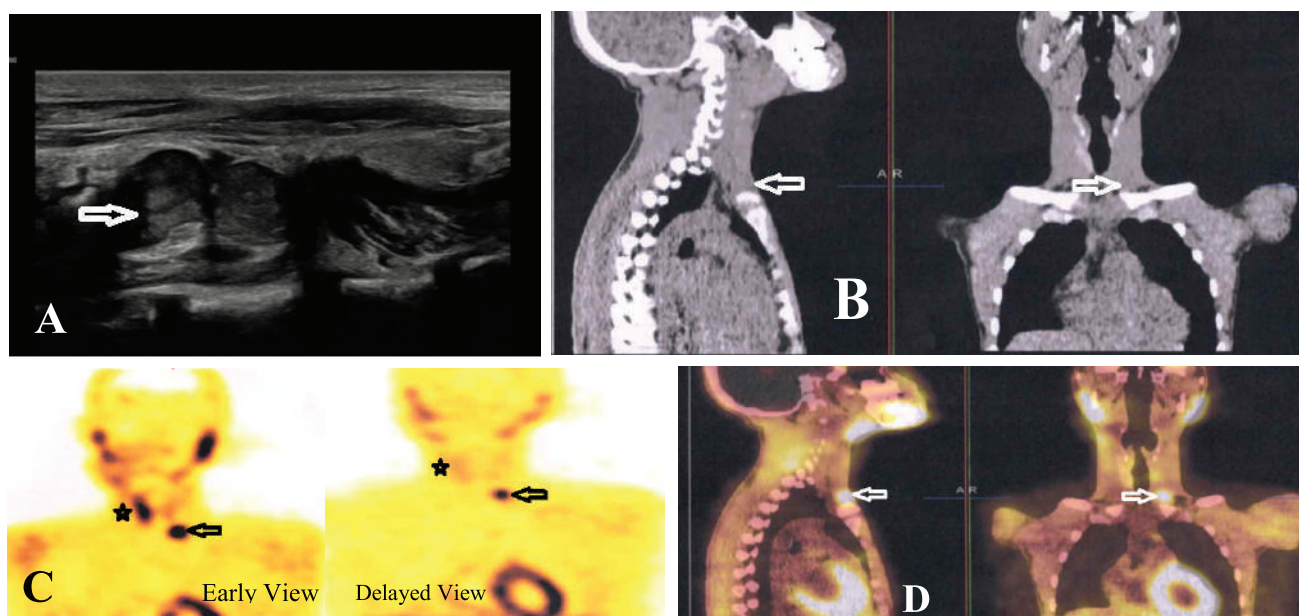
(A) HRUS of neck revealed hypoechoic hyper vascular lesion (white arrow) in the left lower neck, (B) CT Neck showed soft tissue density lesion (white arrow) in the left lower neck, (C) MIBI SPECT early and delayed image: early uptake with rapid washout of right thyroid (black asterisk), while persistently increased tracer uptake in the left lower neck indicates hyperfunctioning parathyroid (black arrow) (D) MIBI SPECT/CT: recurrent PC (white arrow) at left lower neck at D1 vertebral level.
